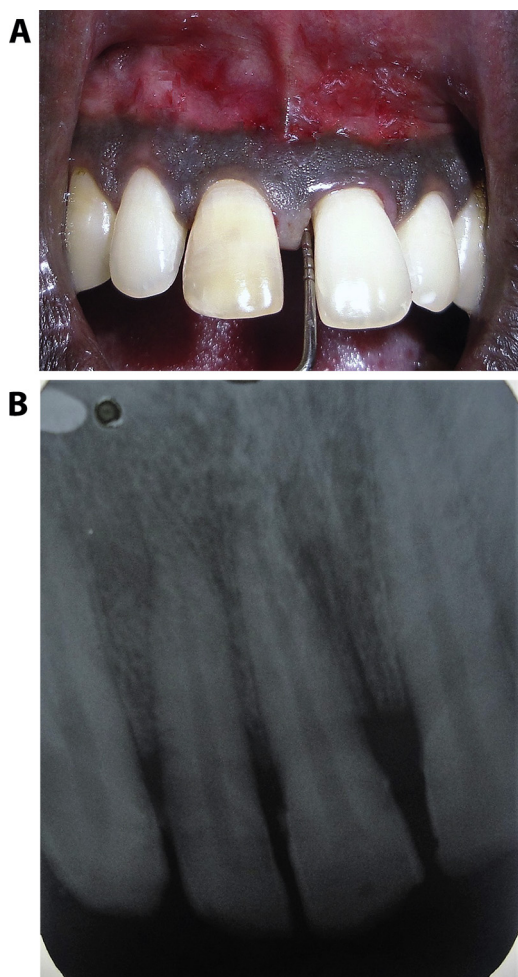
(A) Clinical examination demonstrated a probing pocket depth of 6 mm 21 facial aspect. (B) Radiographic examination revealed loss of bone levels in relation to 21 and 11.
